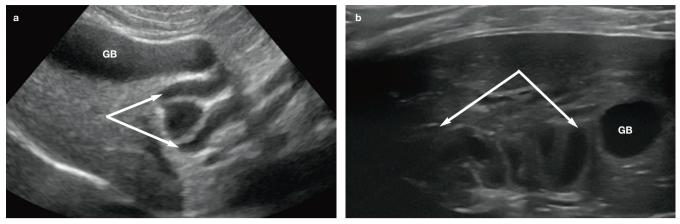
(a,b) Ultrasound images showing the gall bladder (GB) and normal tortuosity of the cystic and common bile ducts (both indicated by arrows)
